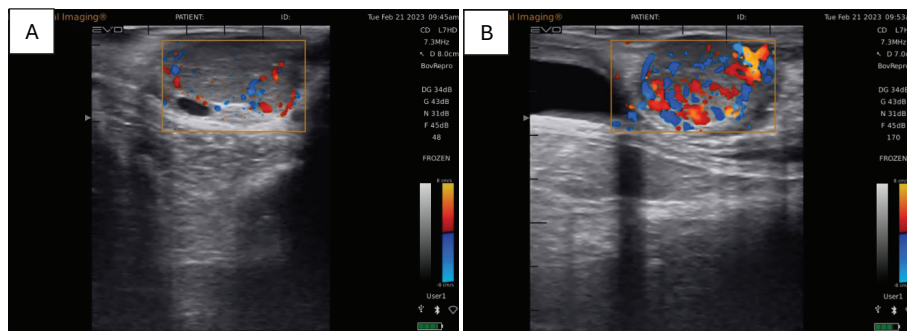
Images of various corpora lutea obtained via transrectal ultrasonography assisted by color flow Doppler imaging; A. Example of a CL considered to have limited blood flow; and B. CL with substantial blood flow
